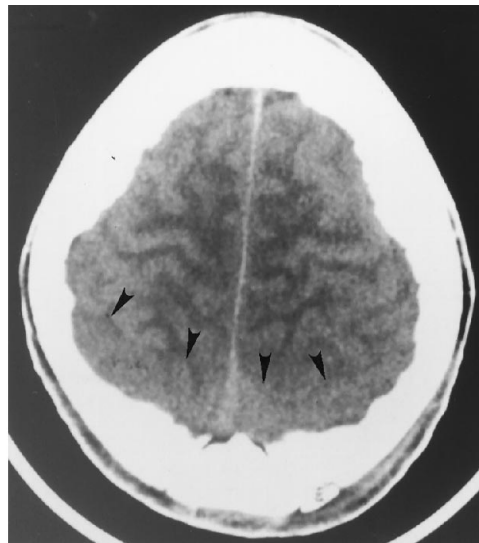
Axial unenhanced CT scan at the level of the upper cerebral hemispheres. The large intracranial component of the scalp mass is very difficult to appreciate in the axial plane (*arrowheads*). The increased thickness of the posterior scalp tissues was overlooked initially.
